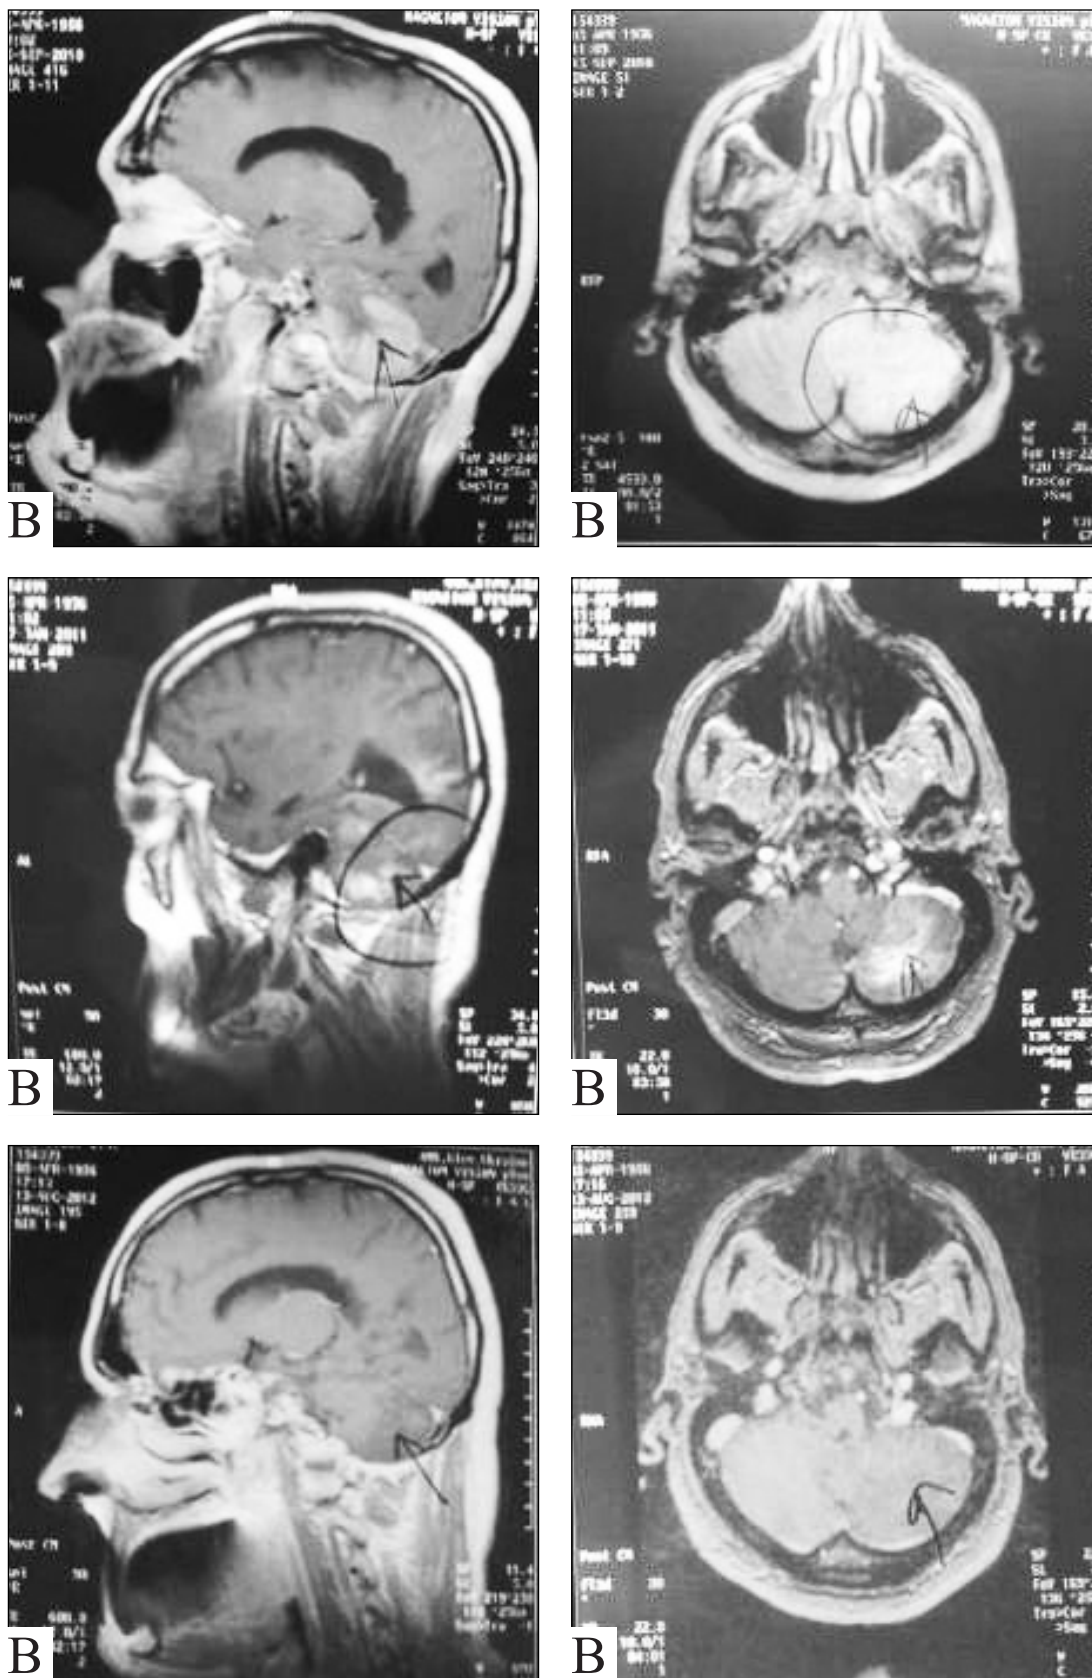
Male, 55 y.o. *A* — Digital subtraction: the lateral and anteroposterior projection. Cavernous hypervascular hemangioblastoma. Afferent — shell branch of ECA. Total ECA embolization. *B* — MRI. Regress of focal symptoms within 1 month after embolization. Within 2 years the patient has underwent 4 follow-up MRI. Reduction of tumor's size. The tumor is not contrasted; in its place scar tissue is found
